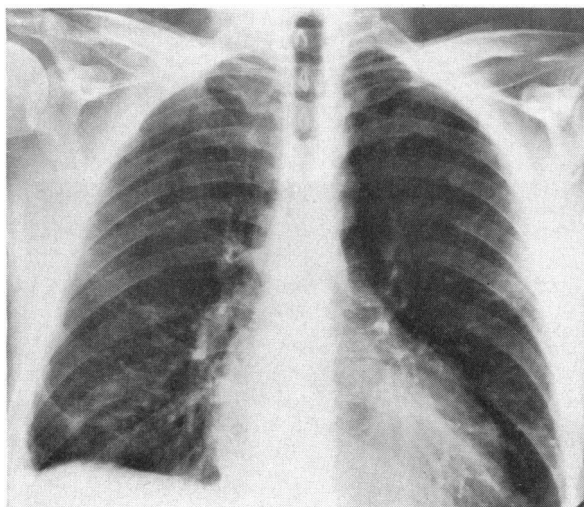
Postoperative x-ray film showing normal appearance of the heart.
